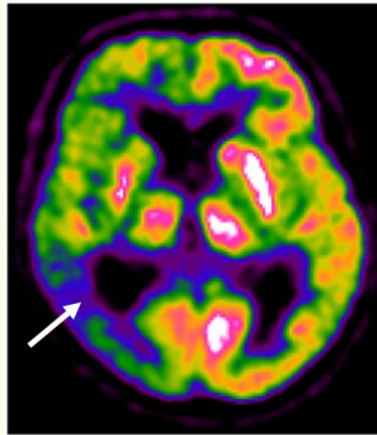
A 76-year-old patient with CBD associated with mild cognitive impairment. The PET-CT study with FDG reveals severe hypometabolism throughout the right hemisphere, including the basal ganglia region and the thalamus, with the most pronounced effects in the temporo-parietal cortex (white arrow) [17].
